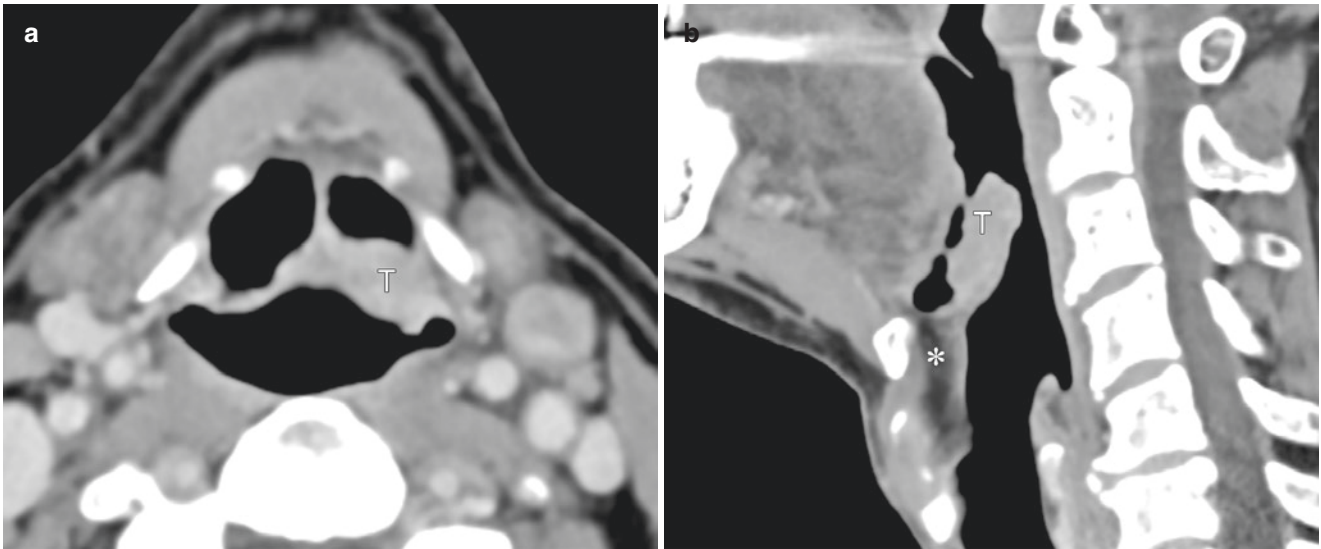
Supraglottic cancer without preepiglottic space invasion. Axial contrast-enhanced CT demonstrated a mass of the left suprahyoid epiglottic (T). On a sagittal image, the tumor was almost limited to the epiglottis, and the fat layer in the preepiglottic space (asterisk) was preserved
